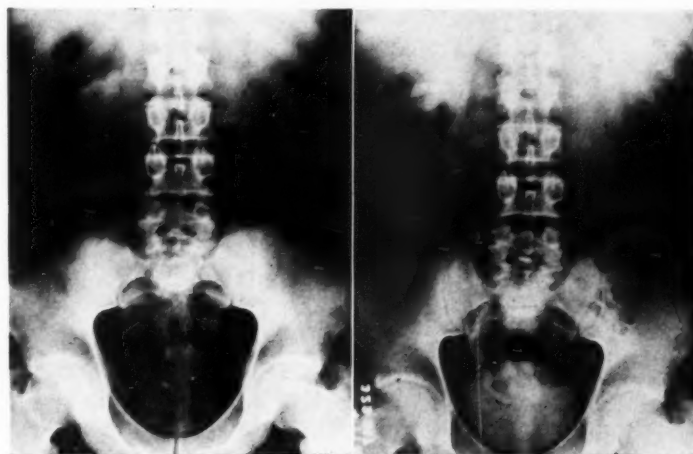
A.* Woman, aged forty-two. Roentgenogram showing a stone in the lower right ureter. *B.* Partial obstruction caused by the stone with dilatation of the ureter and hydronephrosis. Retention after one hour.
